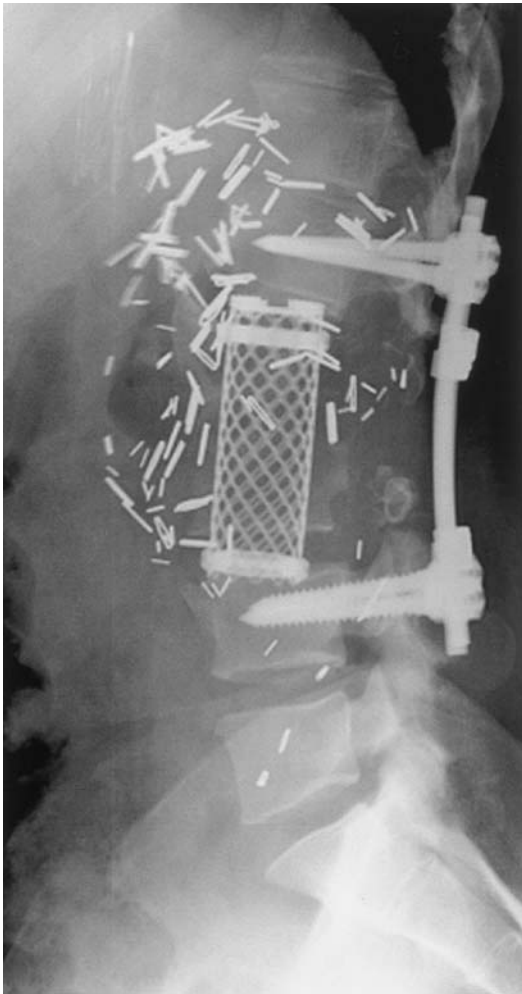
Post-operative lumbar radiograph of a 42-year-old male with a history of metastatic renal cell carcinoma. The patient initially underwent radiation therapy but continued to have severe intractable pain and progressive neurological deficits. The patient went on to undergo a two-stage procedure, including L2 and L3 laminectomies, with L1–L4 posterior segmental instrumentation, followed by a right-sided retroperitoneal approach to the lumbar spine, followed by L2 and L3 corpectomies, with L1–L4 anterior reconstruction using a titanium cage. Prior to surgery, the patient underwent angiography and tumor embolization.
